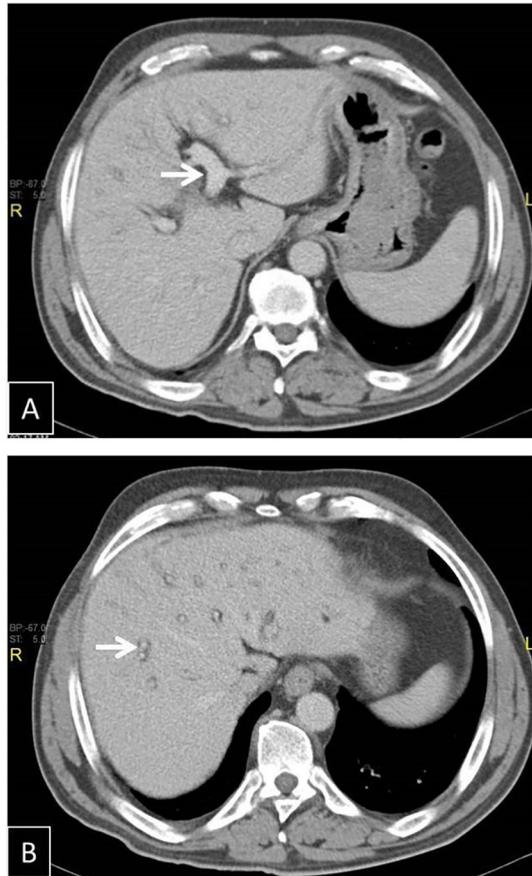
Periportal fibrosis on CT scan. A,B) Contrast enhanced CT images of the liver show diffuse periportal low attenuating areas outlining both sides of portal venous radicles(white arrows).
